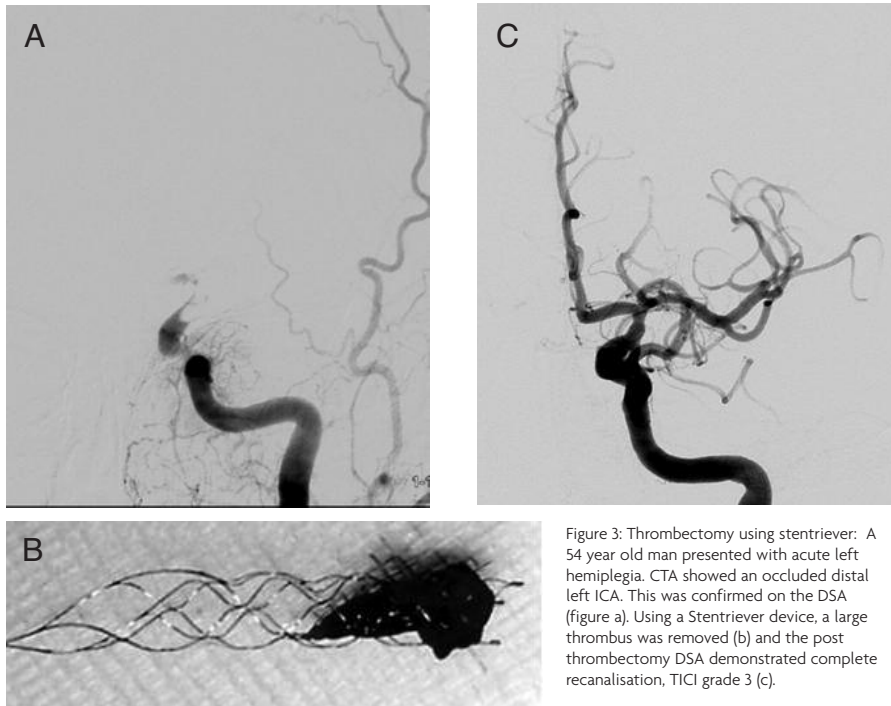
Thrombectomy using stentriever: A 54 year old man presented with acute left hemiplegia. CTA showed an occluded distal left ICA. This was confirmed on the DSA (figure a). Using a Stentriever device, a large thrombus was removed (b) and the post thrombectomy DSA demonstrated complete recanalisation, TIC1 grade 3 (c).
